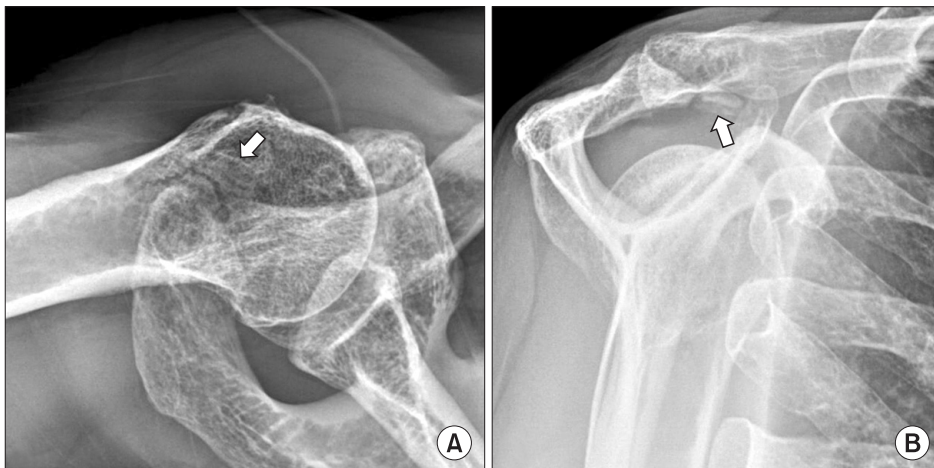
(A) Axial radiograph giving a false impression of pre-acromion (arrow) (B) Y view of the same patient, clearly showing a fractured acromion spur (arrow).
